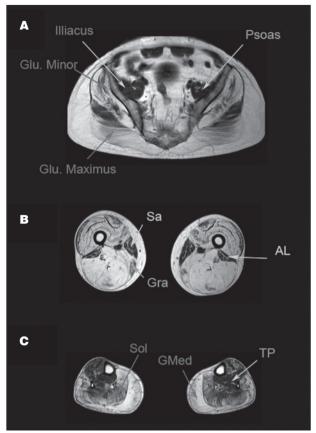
Muscle MRI of a Becker muscle dystrophy patient. A) Pelvic image shows atrophy of glutei muscles (Gluteus minimus and maximus are shown in the image). Psoas and illiacus muscle are usually spared until late stages of the disease. B) Image of the thigh shows a complete atrophy of all muscles, except for sartorius (Sar), gracillis (Gra) and adductor longus (AL). C) Image of the legs showing a severe atrophy of gastrocnemius medialis (GMed) and soleus (Sol). In this patient, tibialis posterior (TP) was not involved.
